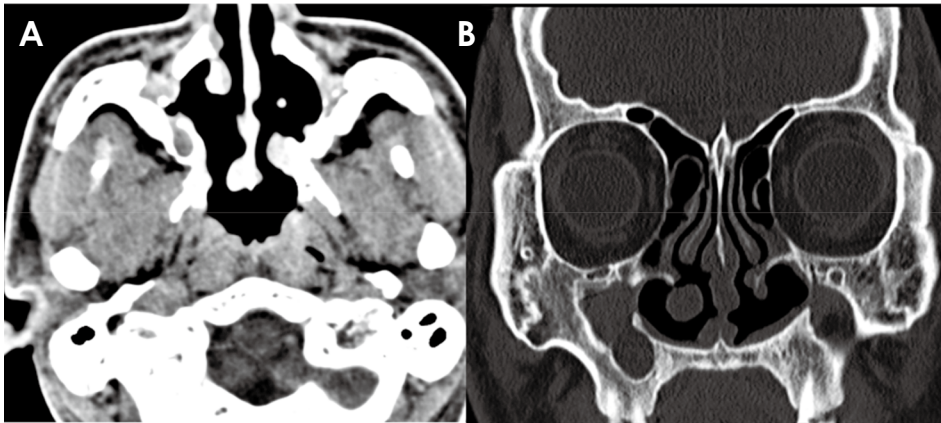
A. An axial computed tomographic image (the first visit, taken 8 years previously) shows bilateral collapse of the right maxillary sinus, suggesting a previous Caldwell-Luc operation. B. Computed tomographic coronal image shows a region surrounded by remodeled bone and aeration loss in the right maxillary sinus, but no distinct expansion can be detected.
